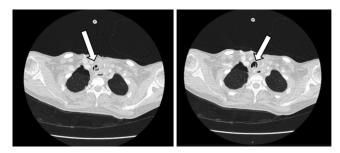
Pseudomembrane tissue in computed tomography
